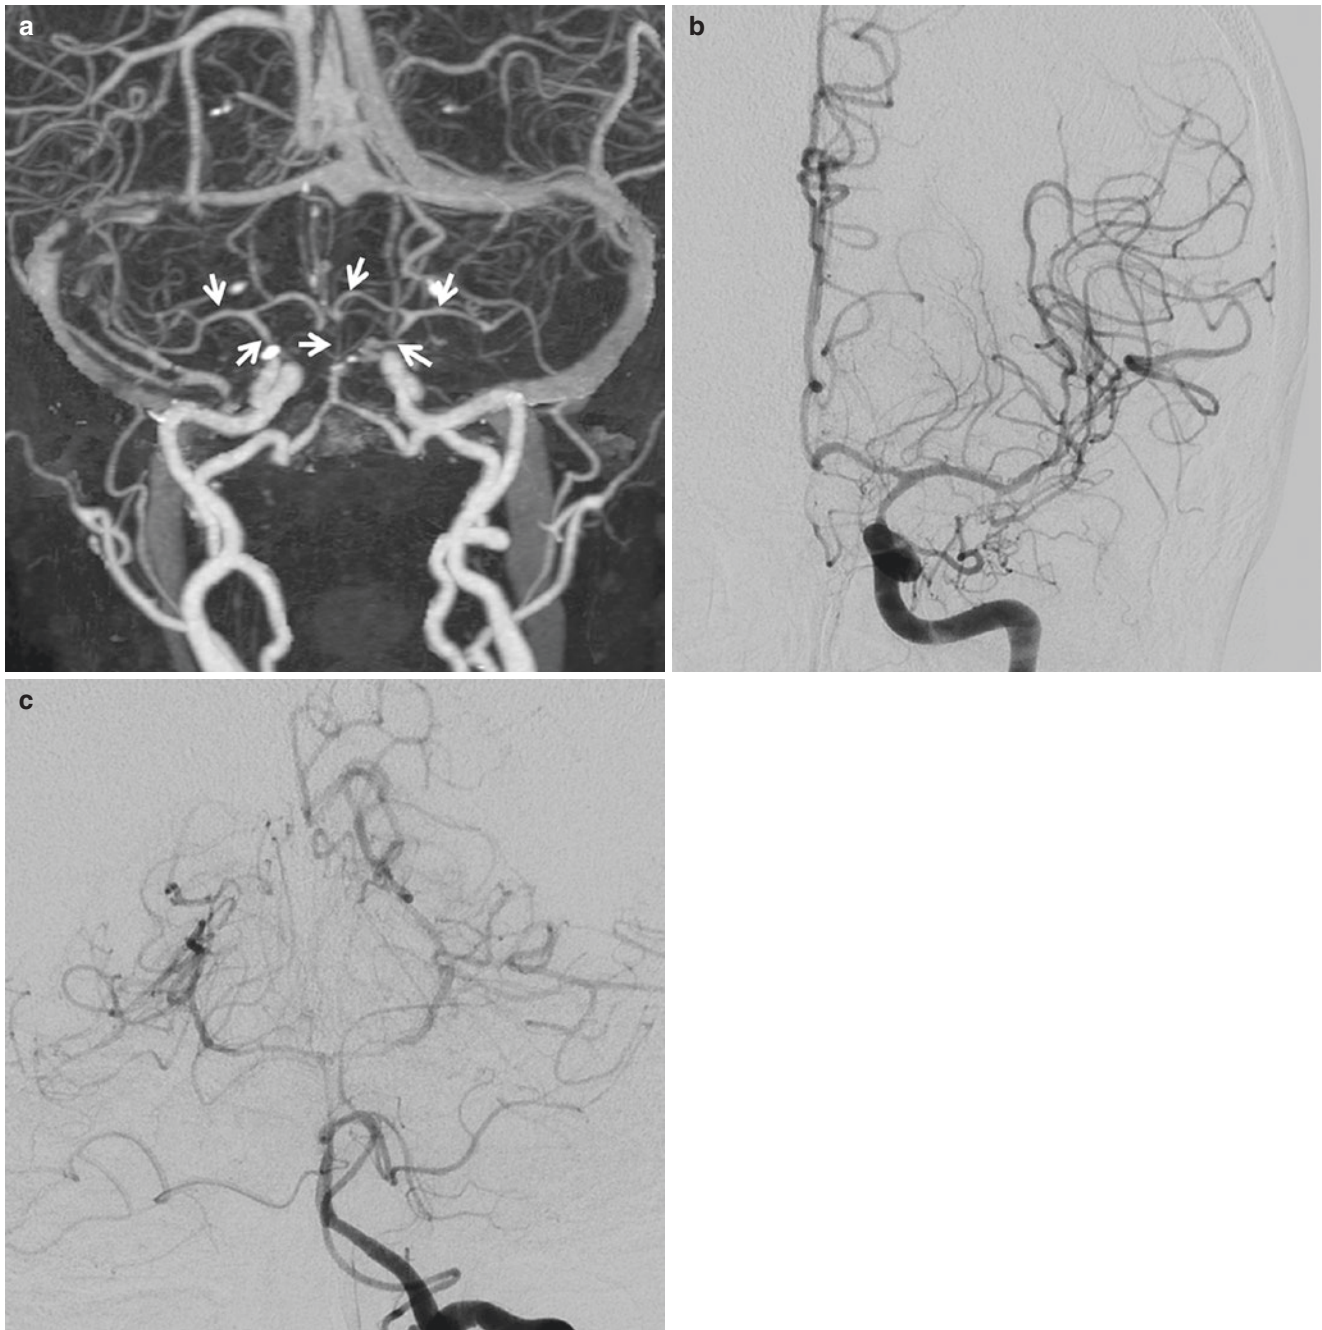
Vasculitis or vasospasm secondary to meningitis. Patient with pneumococcal meningitis develops sudden onset of left-sided weakness. MRI shows acute left parietal lobe infarction (not shown). (a) CTA 3D reconstruction shows diffuse narrowing of the basilar artery and bilateral supraclinoid ICA, MCA, and ACA (arrows) compared to
